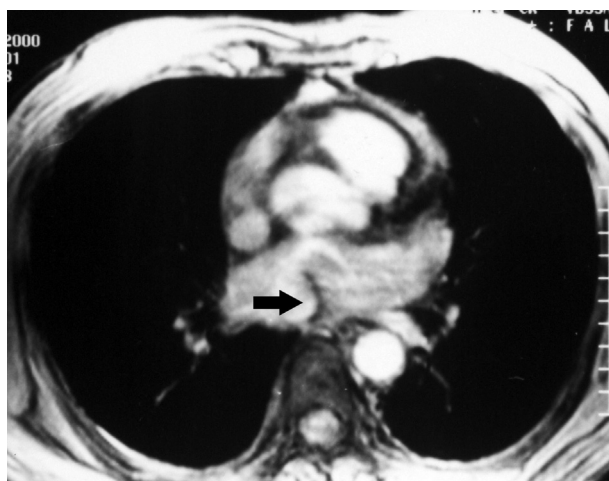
Magnetic resonance imaging reveals the long-axis view of the intra-atrial fibrous membrane (arrow) in the left atrium.
